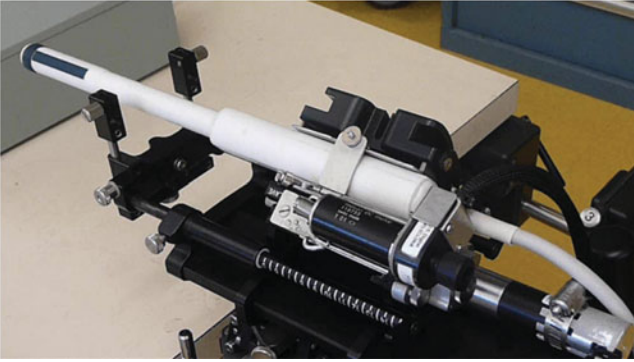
3-D ultrasound acquisition setup based on the brachytherapy stepper. The sagittal plane of the TRUS probe is used to acquire images while rotating along the axis.
